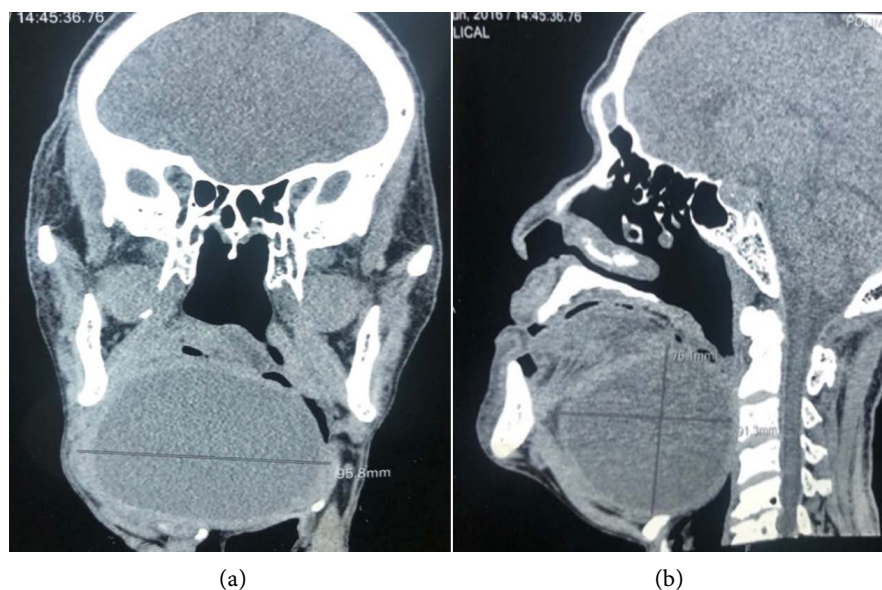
(a) Coronal CT scan with contrast injection showing a cyst developed at the expense of the floor with peripheral enhancement. (b) Sagittal CT scan with contrast injection showing a cyst developed at the expense of the floor with peripheral enhancement.
